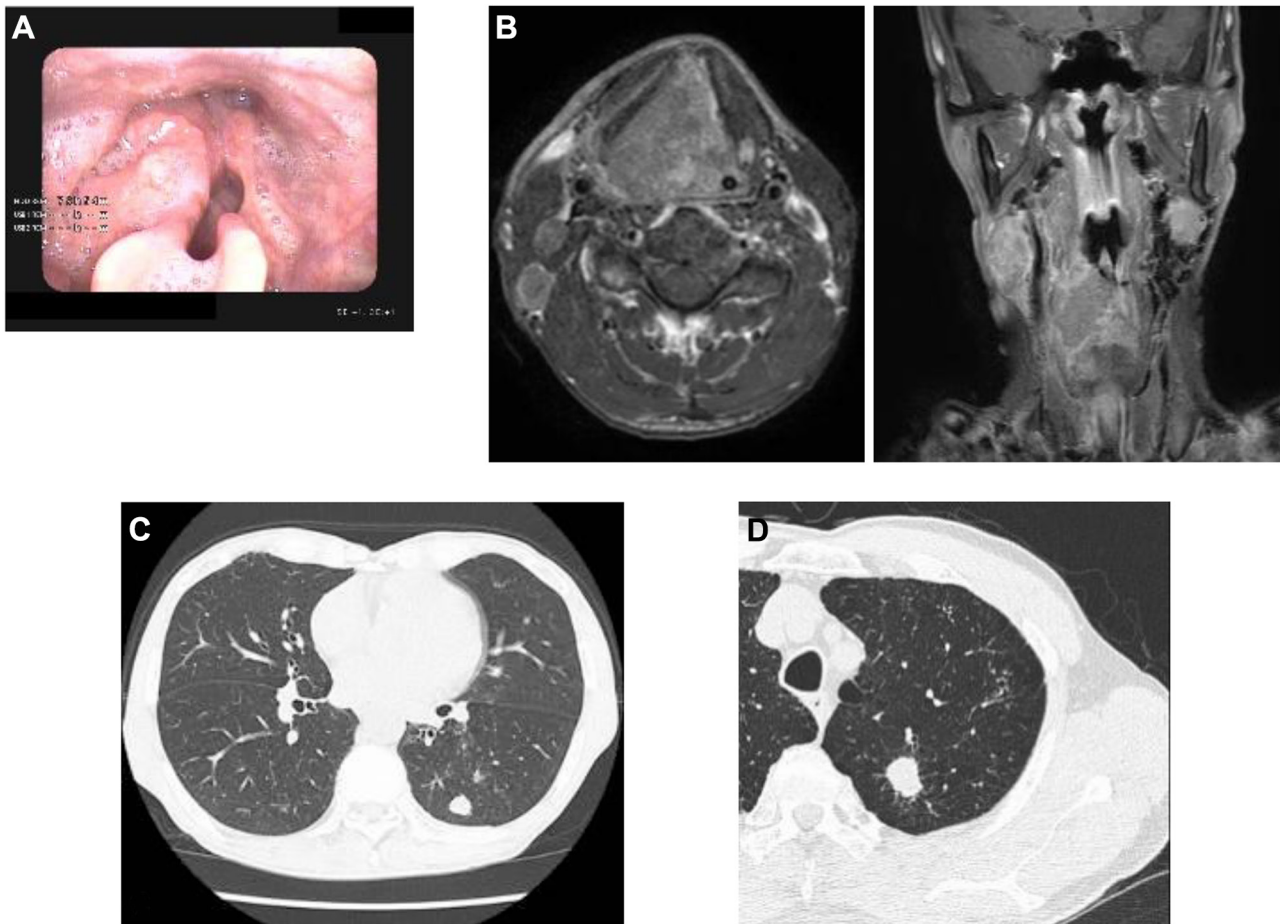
Clinical examination. (A) Laryngofiberscopic findings: Right vocal fold paralysis is noted, and airway stenosis is present because of compression by the hypopharyngeal carcinoma. (B) T1-weighted contrast-enhanced magnetic resonance imaging (B: axial) of hypopharyngeal carcinoma, likely originating from the right pyriform sinus, shows destruction of the thyroid cartilage. Multiple metastatic lymph nodes are noted in both sides of the neck. Lymph node metastases are seen in both sides of the neck. (C) Lung window computed tomography (CT) of a metastatic lesion in the left lung field. (D) Lung window CT of a new metastatic lesion appearing approximately three years after starting nivolumab therapy.
